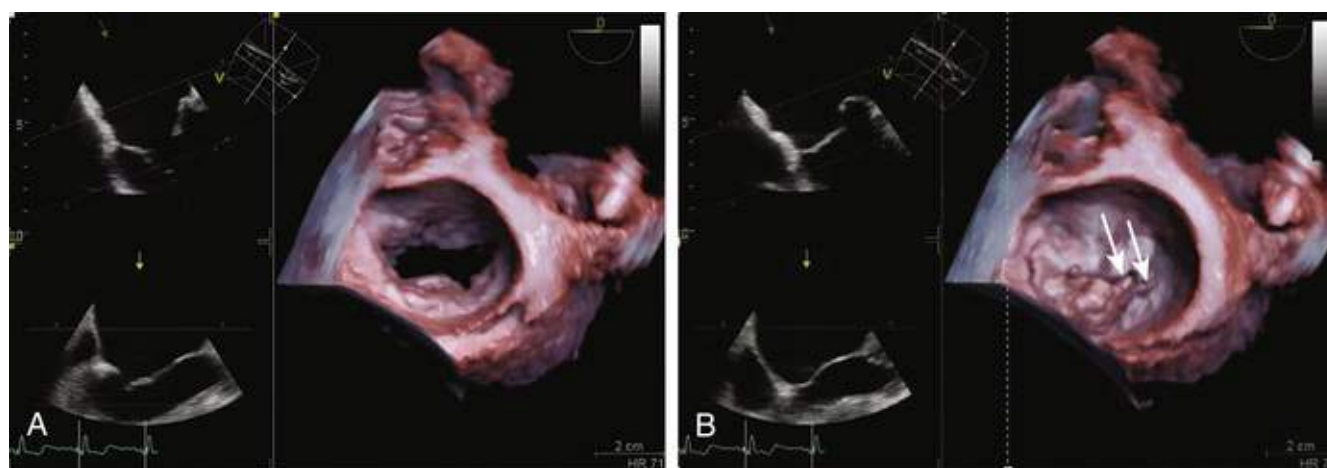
Three-dimensional echocardiography now allows direct visualization of the pathology, here demonstrating ruptured chordae to P₂ and P₃ (arrows). A, Ventricular diastole; B, systole.
